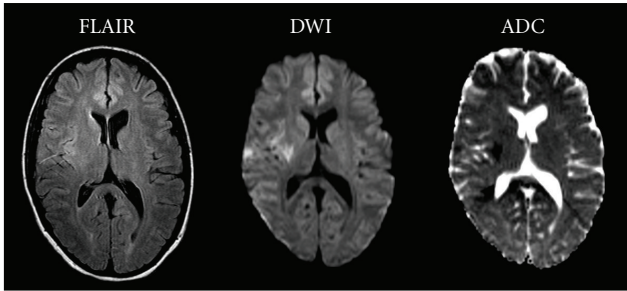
Case 4: acute MRI with FLAIR, DWI and ADC showing an established infarction in the right basal ganglia that was not detected by the CTP examination.
